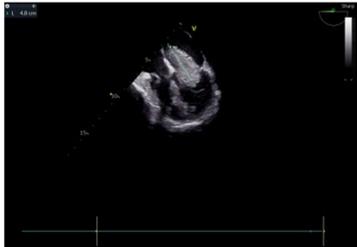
Intraoperative transesophageal echocardiography showing left atrial myxoma.
